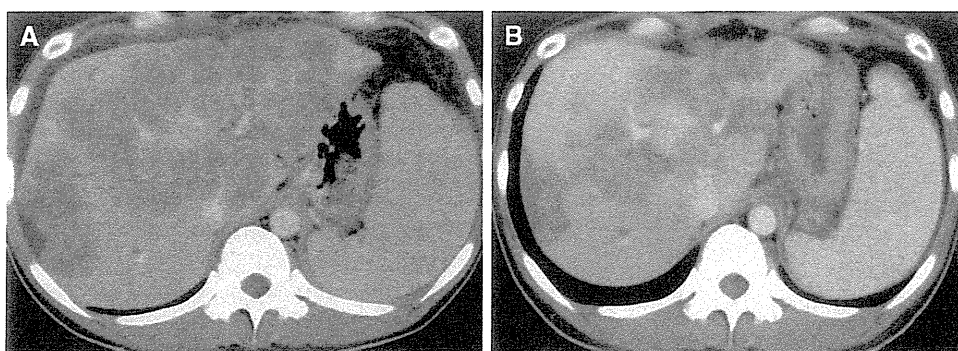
A 40-year-old female with multiple liver metastases refractory to FOLFOX plus bevacizumab and irinotecan. a CT scan acquired prior to cetuximab monotherapy. She had icterus accompanied by serum total bilirubin of 8.9 mg/dl. b CT scan acquired after
